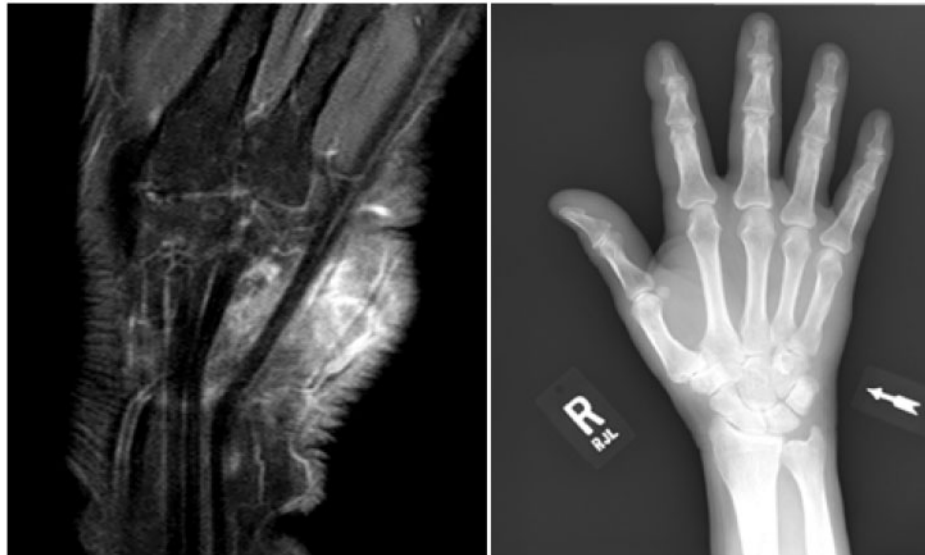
Magnetic resonance imaging without contrast showing a mass on the right wrist measuring $4.2 \times 2.4 \times 3.8$ and located medial to the carpal tunnel and deep to the flexor carpi ulnaris tendon along the course of the abductor digiti minimi tendon.
